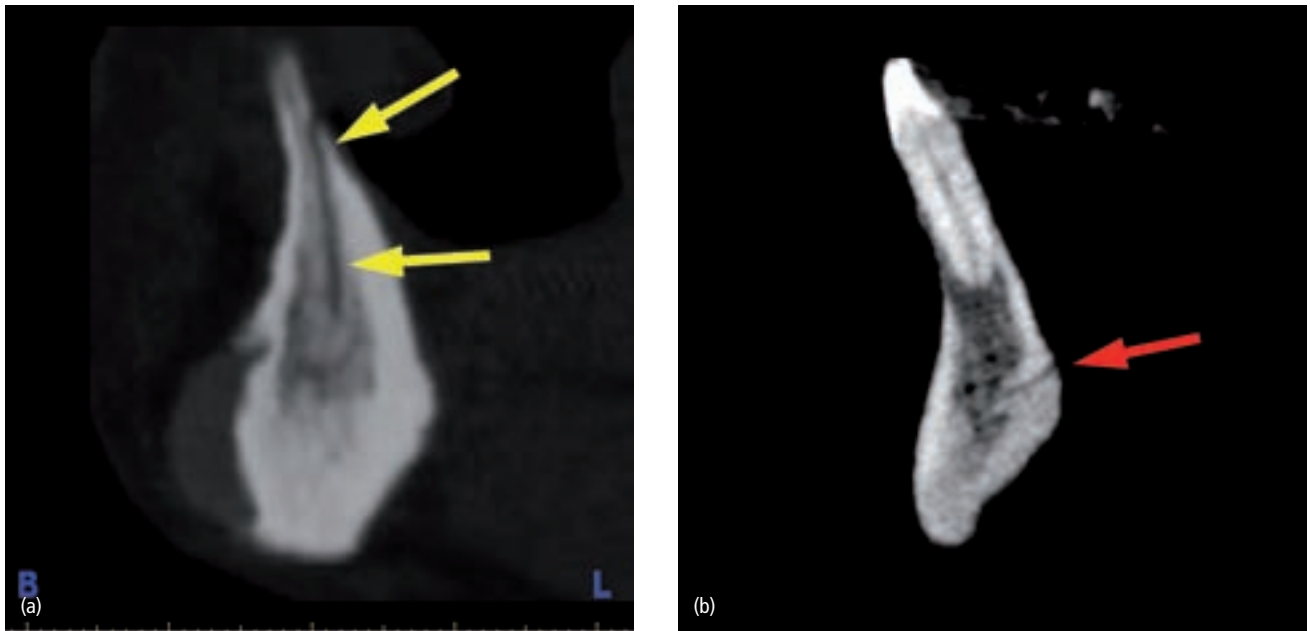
(a) CT/CBCT scan allowing inspection of the intraforaminal region, which may contain vessels and nerves that should be avoided when placing implants; (b) lingual artery found in the cross-sectional view.
